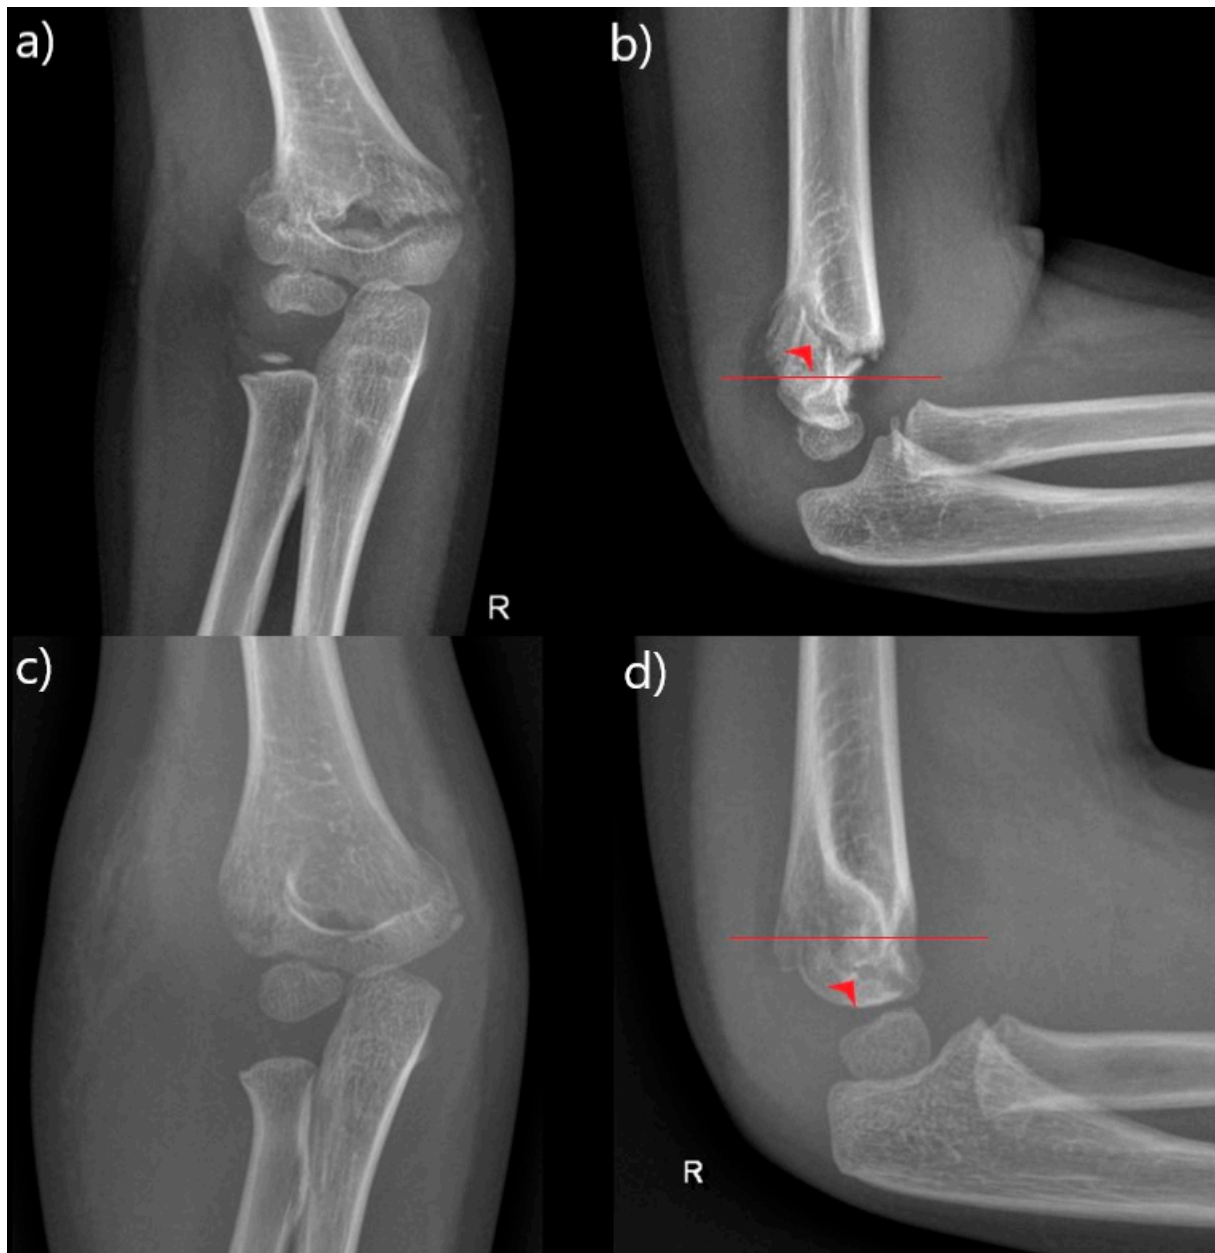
Anteroposterior and lateral x-rays of supracondylar fractures; (a,b) - high type of supracondylar fracture of the right humerus in a four-year-old boy; (c,d) - low type of supracondylar fracture of the right humerus in a five-year-old girl (red line - isthmus of the humerus, red arrow - fracture)
